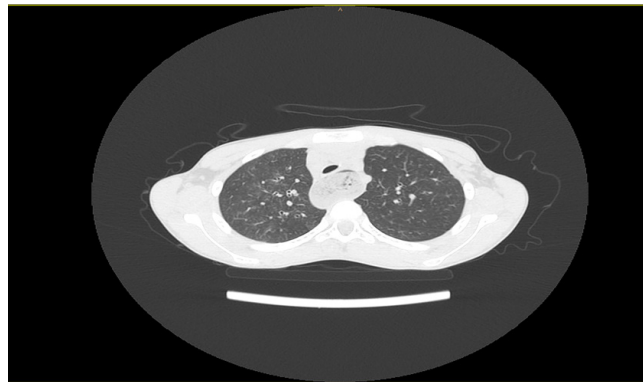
Coronal HRCT image revealing marked esophageal dilation measuring up to 6 cm in diameter.
